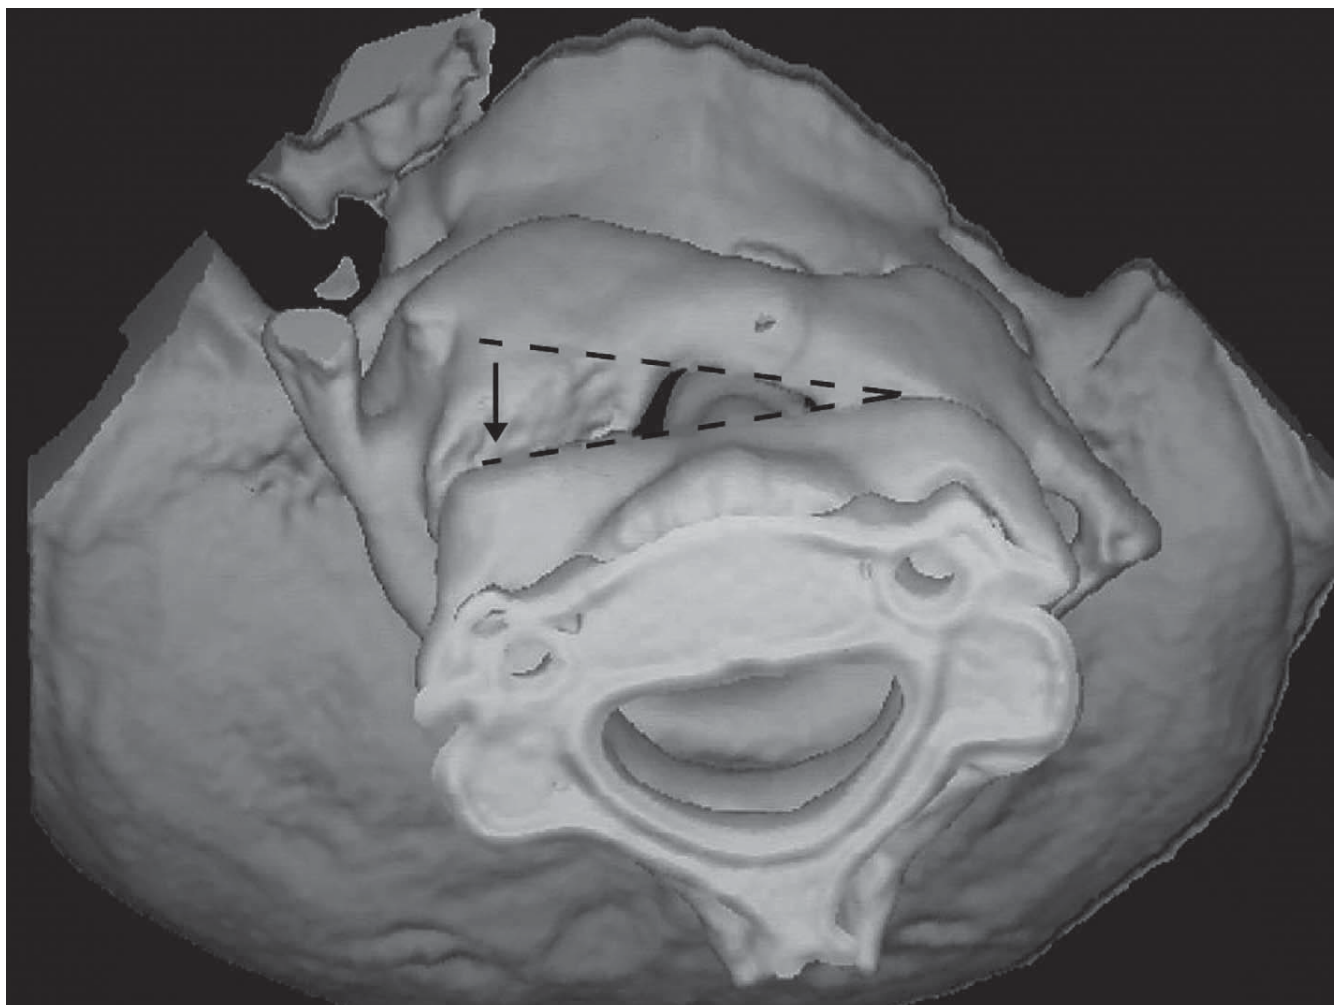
Inferior view of CT 3-dimensional reconstruction of the traumatic rotatory atlantoaxial subluxation in Case 1. The separation of the inferior articular facet of the atlas from the superior articular facet of the axis can clearly be seen (arrow).
